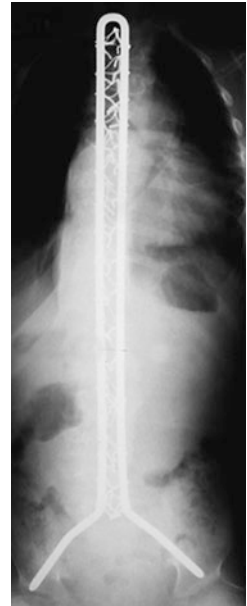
The postoperative radiograph of the Modular Unit rod
